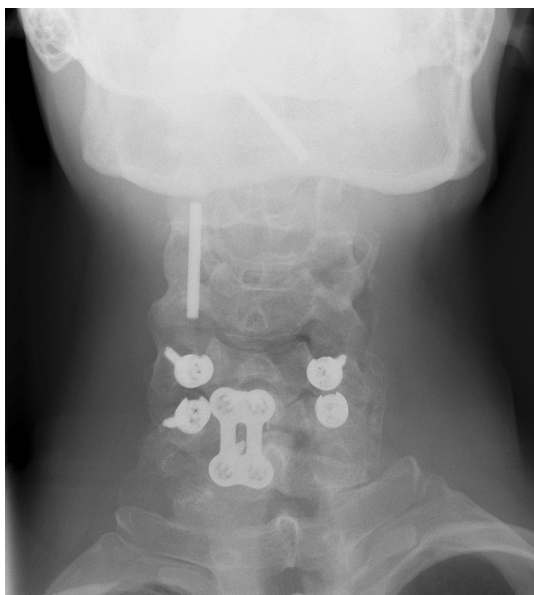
X-ray cervical spine (ap view). Position of the dislodged rods in the neck and near the Foramen magnum
